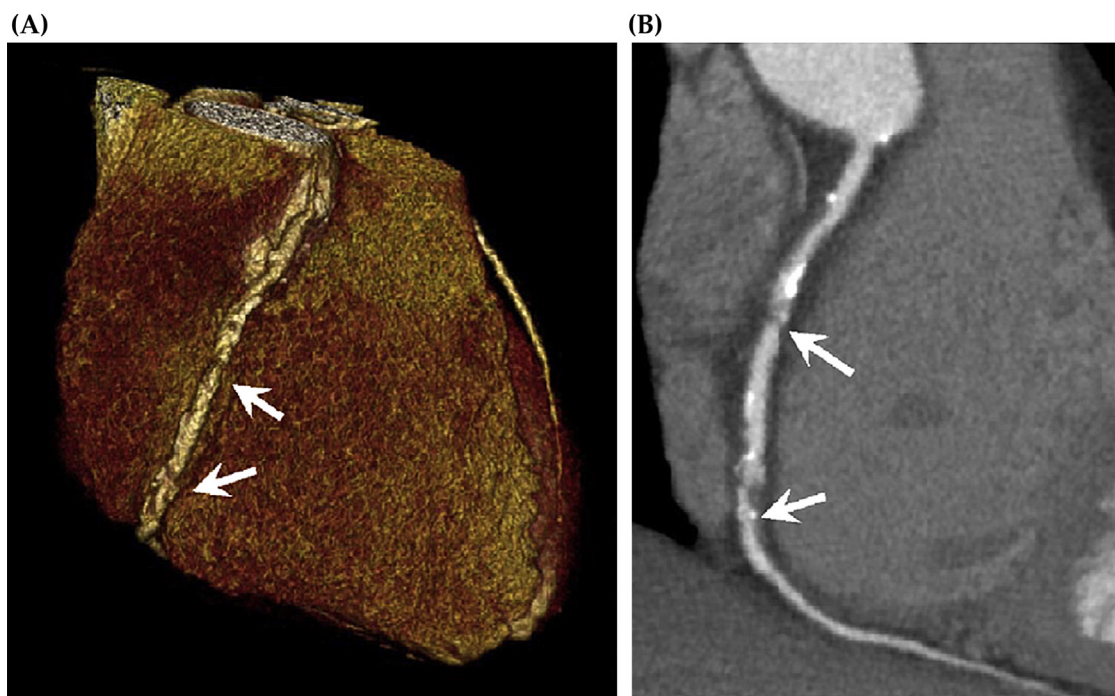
Coronary artery disease detected by CTA in a 68-year-old patient who presented with suspected acute coronary syndrome. Reconstruction of the right coronary artery exhibits significant coronary lesions (A) and coronary calcifications (B; arrows). Adapted from de Graaf et al. [146].
